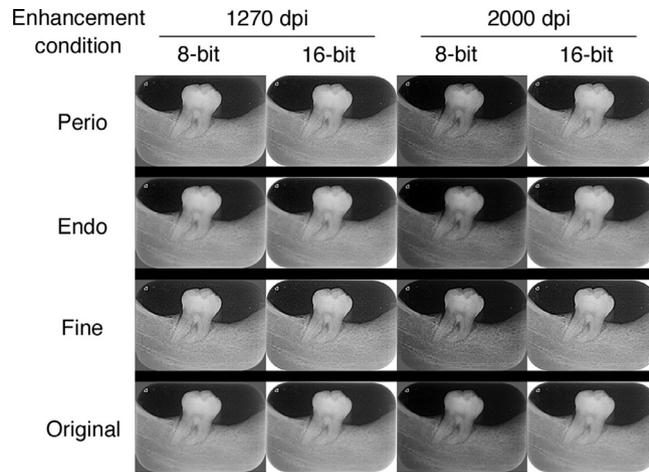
Representative radiographic images under different conditions of spatial resolution, bit depth, and image enhancement.
